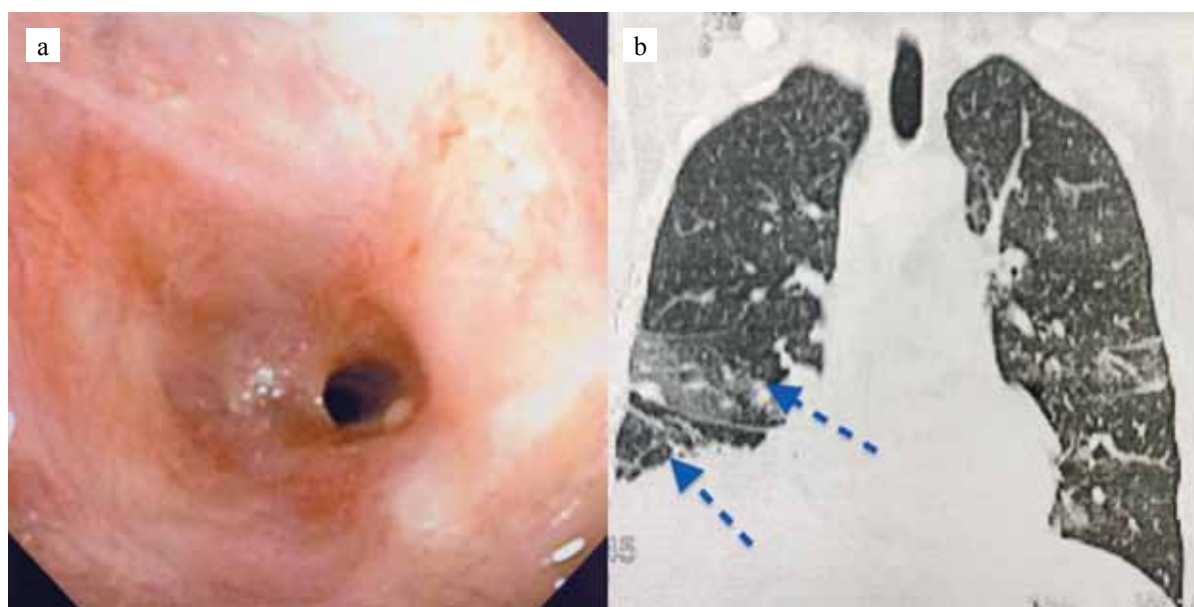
Development of restenosis after balloon dilatation; a – narrowing of the lumen of the bronchus intermedius; (d ~ 3–4 mm); b – CT signs of pneumonia (indicated by arrow)
